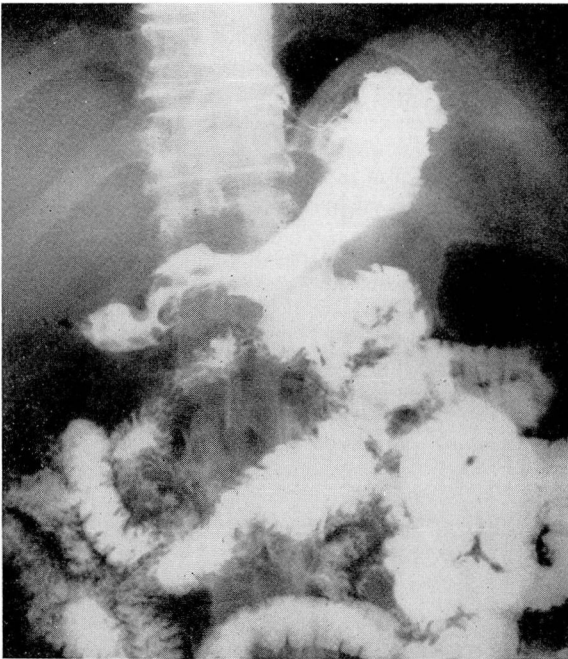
Case 1. Roentgenogram of stomach. A functioning gastroenterostomy is demonstrated. Distal to this may be seen narrowing of the antrum and a large filling defect. This proved to be an inoperable carcinoma.
